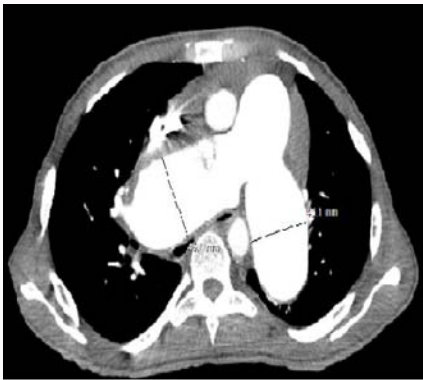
Main pulmonary artery dilatation with right and left pulmonary artery enlargement (Chest computed tomography scan with contrast protocol).
